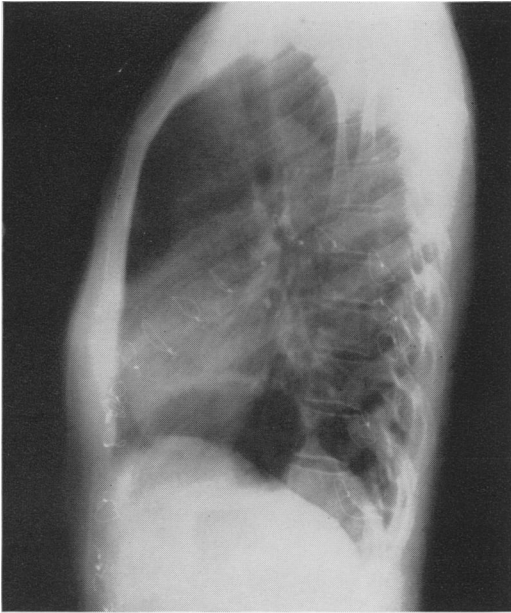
Case 2. Lateral x-ray film demonstrating metal sutures outlining the prosthesis.
